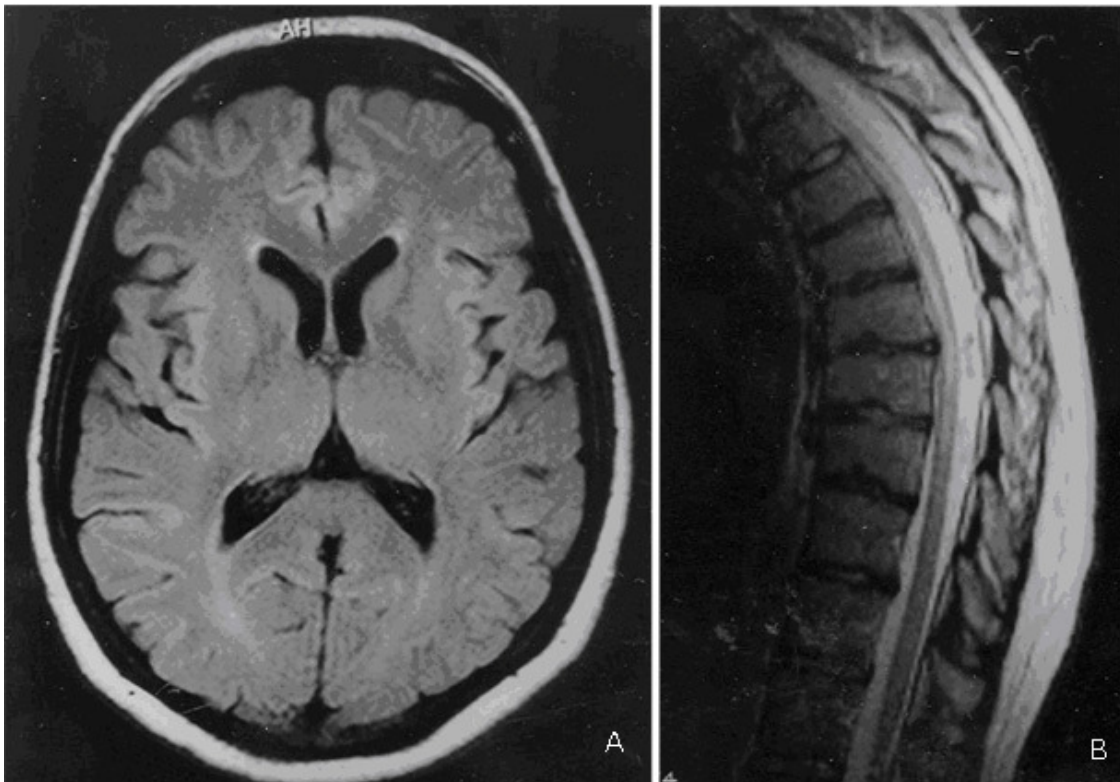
A 34 year old woman had the onset of optic neuritis that resolved with corticosteroid therapy. Soon after, she had a series of relapses with incomplete, and finally complete paraparesis. The disease was temporarily stopped after plasmapheresis, but soon started again and patient died two years after onset of the disease. MRI showed LETM demyelination in T2 images, and extensive destruction in T1 images.
